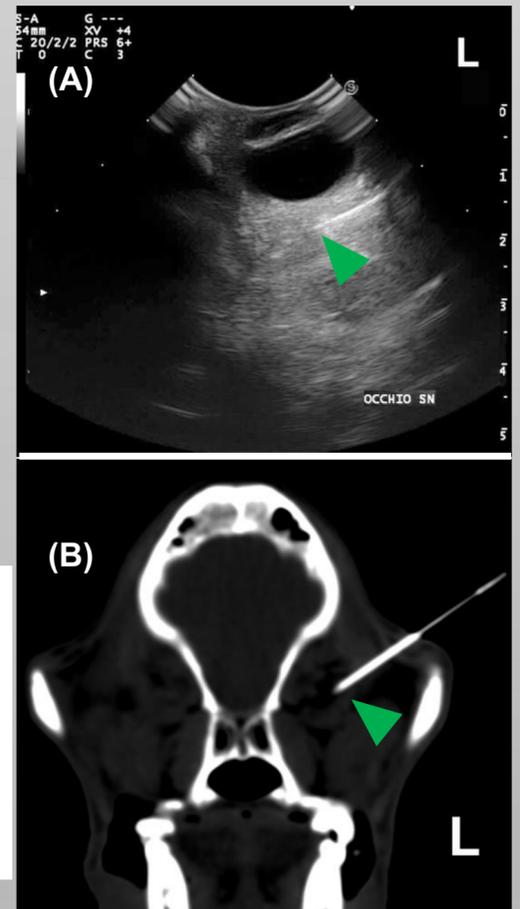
(A) Ultrasonographic image showing the position of the needle tip (green arrowhead) in the Le retrobulbar cone before the injection. (B) Transverse CT image of the skull obtained after needle insertion (green arrowhead) to assess the correct positioning within the Le retrobulbar space
